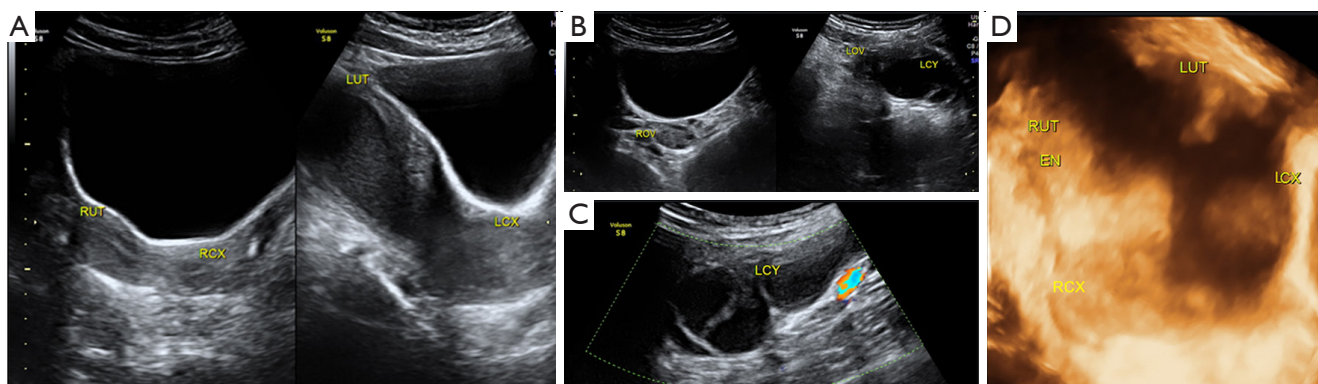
Type II-b UGTOIRA syndrome: U3b-C3b-V0, complete bicorporal uterus, double cervix with left obliterated external cervical orifice, with a normal vagina, without communication, hemorrhage filled in the left uterine cavity and cervical canal, left ovary with an endometriotic cyst, left hematosalpinx, and left renal agenesis. Sonograms were obtained from a 19-year-old female patient after the second operation, and the ultrasonic findings before the first 2 operations were the same as those from this ultrasonic examination (because the first operation was performed for the left-high OVS and the left external cervical orifice atresia, the adhesion atresia of the OVS and the external cervical orifice occurred after the operation, and the same situation occurred after the second operation). (A) TAS 2D sagittal pelvic planes demonstrating a normal right uterus, cervix, and vagina (left side of the figure), dense floating echogenic dots in the left uterine cavity and cervical canal with obliterated external cervical orifice (right side of the figure). (B) TAS 2D sagittal sections of the bilateral ovaries demonstrating a normal right ovary and a left ovary with an endometriotic cyst. (C) TAS 2D sagittal planes demonstrating left hematosalpinx. (D) TAS 3D coronal plane of the uterus under stereoscopy demonstrating complete bicorporal uterus, double cervix with left obliterated external cervical orifice, and hemorrhage filling in the left uterine cavity and cervical canal. RUT, right uterus; RCX, right cervix; LUT, left uterus; LCX, left cervix; ROV, right ovary; LOV, left ovary; LCY, left cyst; EN, endometrium; UGTOIRA, unilateral genital tract obstruction with ipsilateral renal anomaly; OVS, oblique vaginal septum; TAS, transabdominal sonography; 2D, 2-dimensional; 3D, 3-dimensional.
